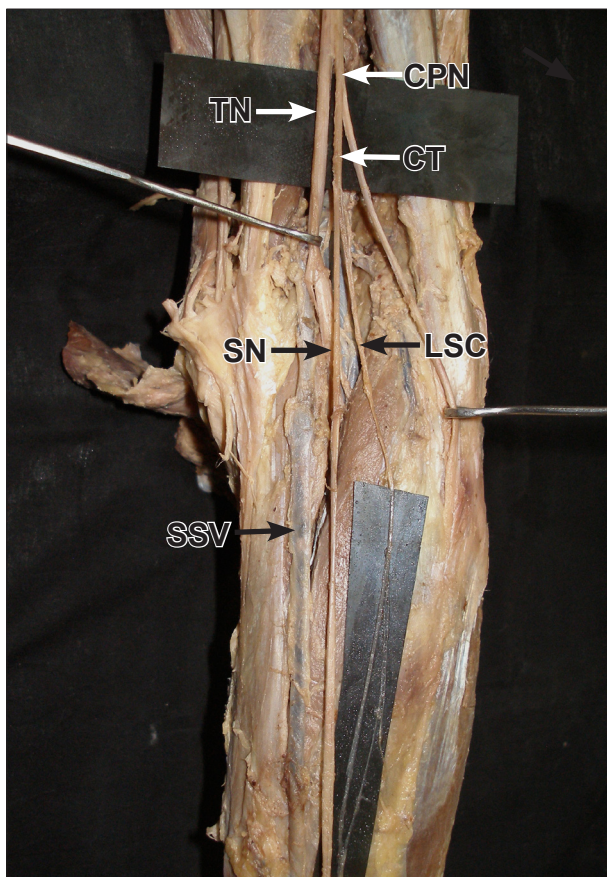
Dissection of the popliteal fossa and back of leg showing the variation of sural nerve and its course. (TN: tibial nerve; CPN: common peroneal nerve; CT: common nerve trunk; SN: sural nerve; LSC: lateral sural cutaneous nerve; SSV: small saphenous vein)
